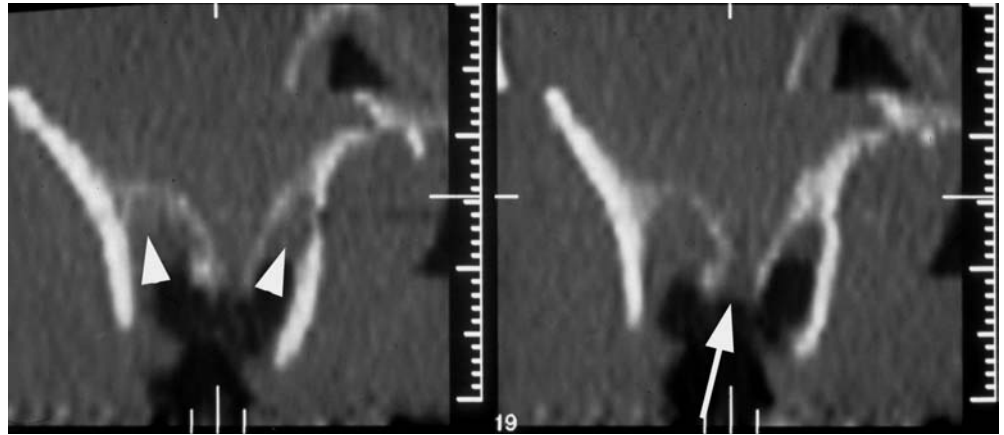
Dental CT of the mandible demonstrating a dentigerous cyst (*arrow*) arising from tooth 35. Adjacent roots are reached but not surrounded by the cyst
